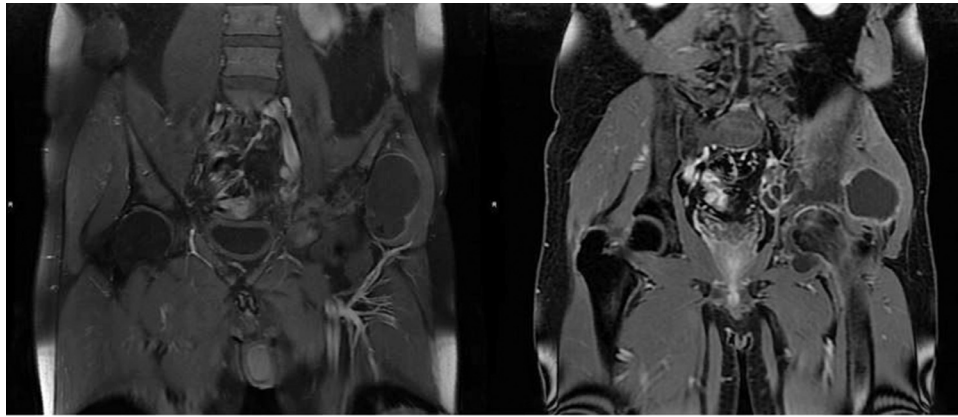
MR with T1-weighted image demonstrates extensive area of osteostructural alteration of the iliac wing and the left acetabular roof for the presence of multiple cystic formations with enhancement of the walls after administration of Gadolinium-based contrast agents.
